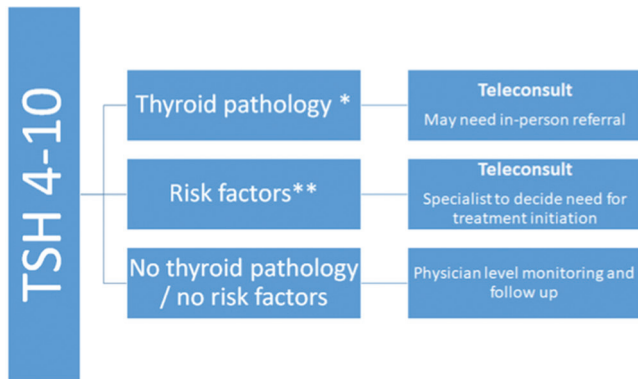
Forward triage for patients with Grade IA subclinical hypothyroidism. \*Thyroid pathology – clinical examination for goiter and thyroid antibodies, ultrasonography suggestive of diffuse hypoechoogenicity \*\*Risk factors – Younger age, female gender, planning pregnancy/already pregnant/infertility, hypertension, dyslipidemia, and cardiovascular disease
